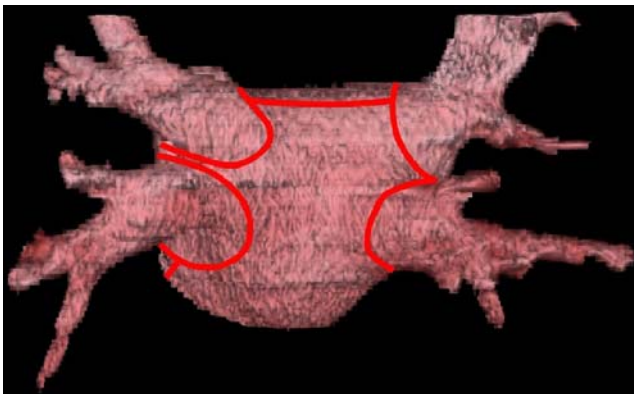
Location of linear lesions made during ablation. Postero-superior 3D CT image of a segmented left atrium with approximate location of linear lesions
